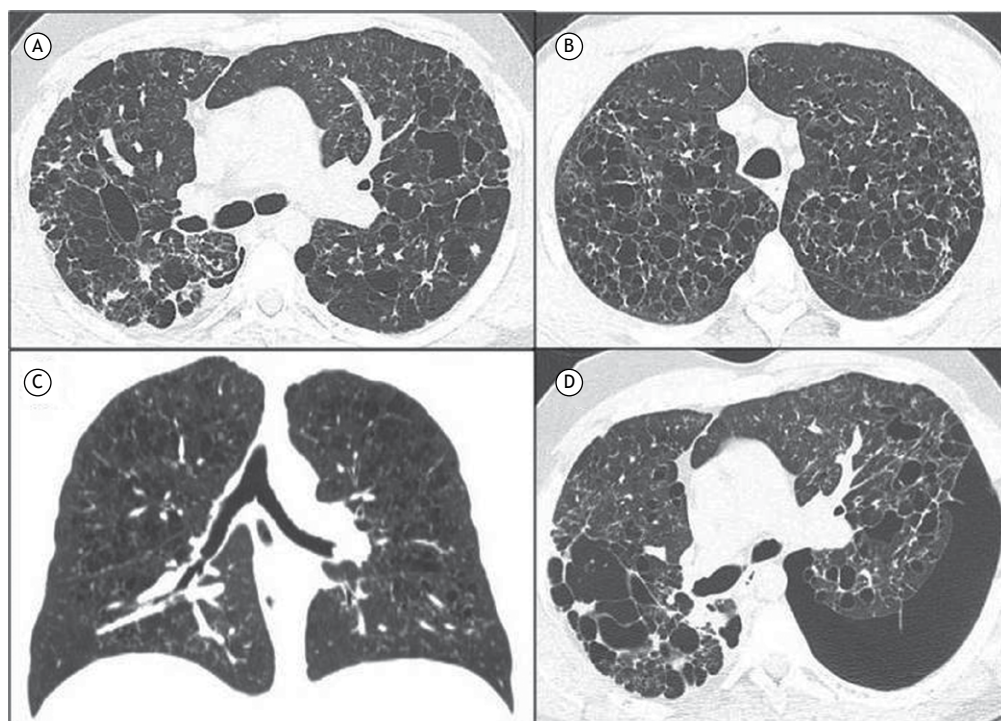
CT scans of patients with pulmonary Langerhans cell histiocytosis. In A, irregular cysts and irregularly margined centrilobular nodules in the upper lobes (axial reconstruction). In B, irregular thin-walled cysts (axial reconstruction). In C, irregular cysts predominating in the upper lobes and sparing the region of the costophrenic sinuses (coronal reconstruction). In D, irregular cysts, some centrilobular nodules, and a left pneumothorax (axial reconstruction).
